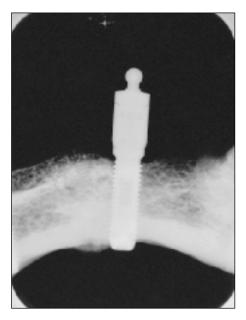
Radiograph of right mandibular lateral incisor region (original mandibular bone) irradiated with 72 Gy.
